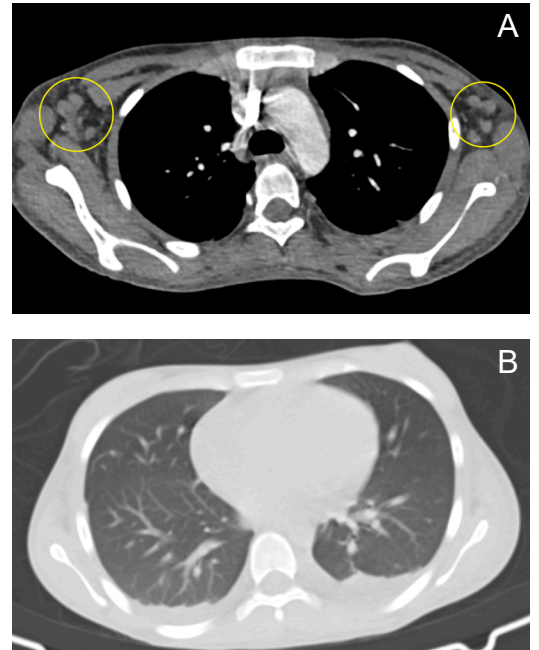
Axial views of the contrast-enhanced CT scan of the chest. Multiple enlarged, enhancing lymph nodes are seen on both axillae (A: yellow rings). Crescentic hypodense fluid collections are observed in the dependent portions of both pleural spaces, with a greater volume on the left than on the right (B).
